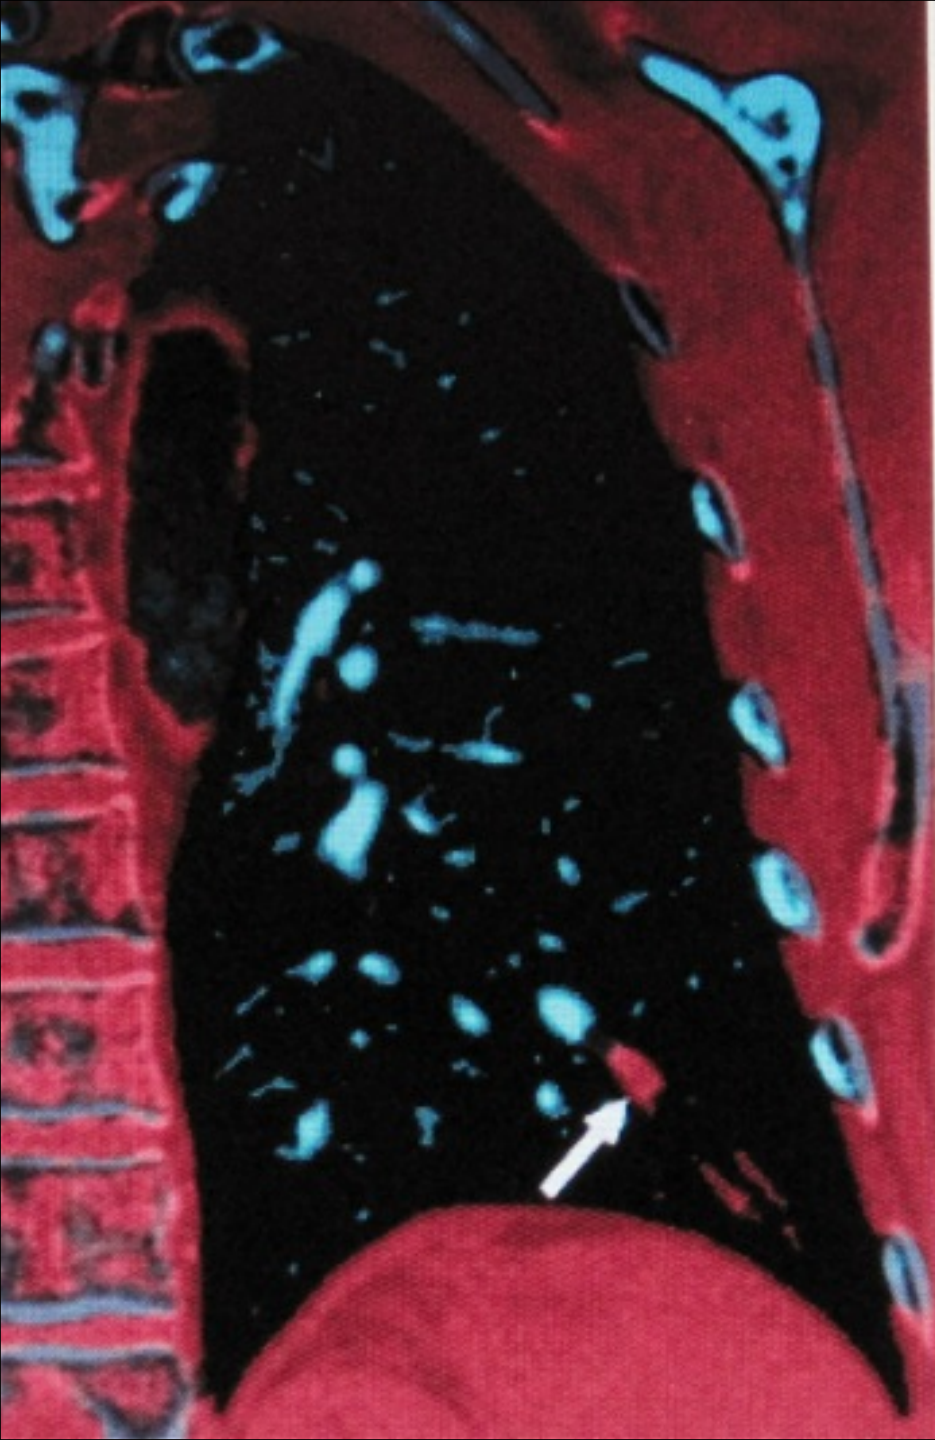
Acute pulmonary embolism in 42-year-old woman. Dual-source CT-based dual-energy CT (DECT) angiography images of lungs are shown as coronal reformations.
